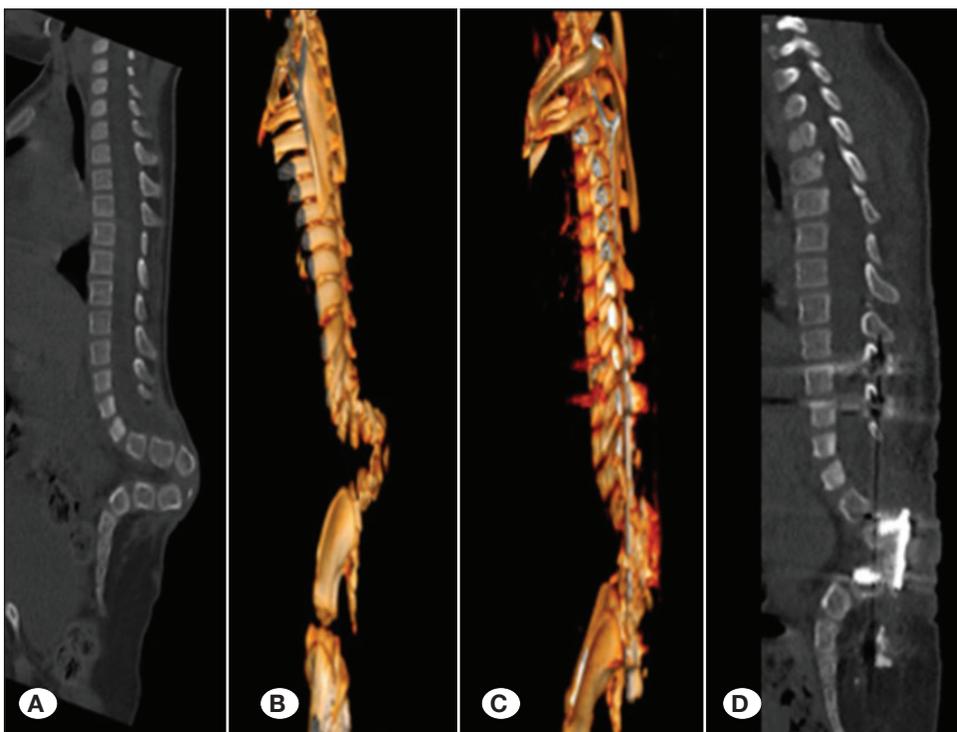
Preoperative reconstructed sagittal Computed Tomography (CT) scan (A) and Three Dimension (3D) CT scan (B) shows sharp angled lumbar kyphosis in 35 months old boy. Successful surgical correction was achieved with screw-rod system (C) and plate system (D) in this case.
